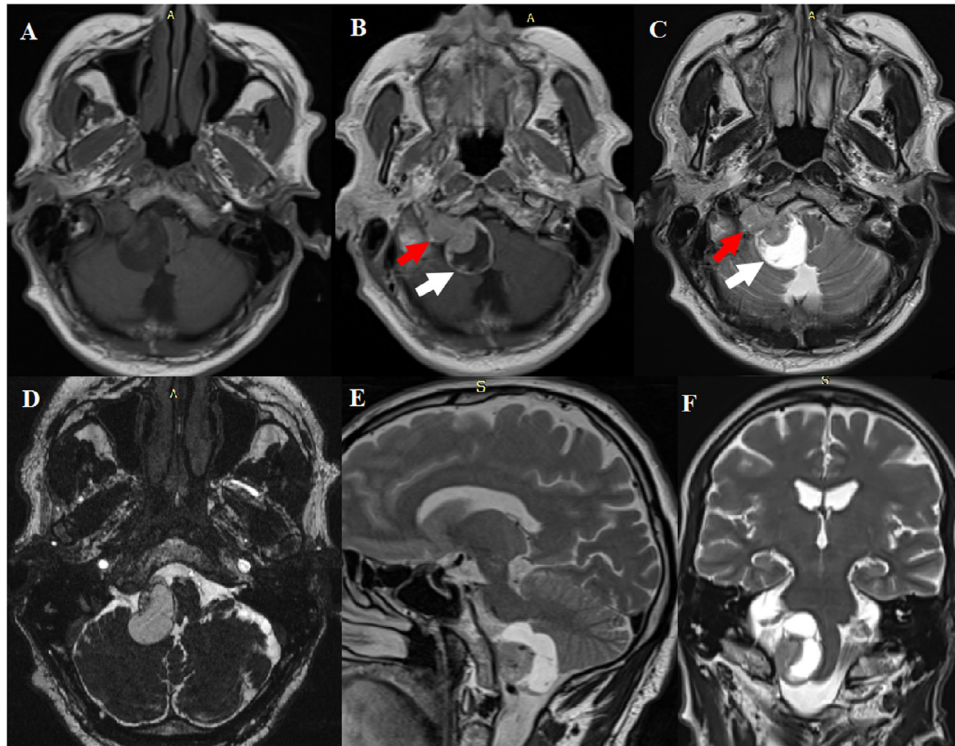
Preoperative Brain Magnetic Resonance Imaging (MRI) axial T1-WI (A), axial T1-WI with gadolinium (B), axial T2-WI (C), axial Constructive Interference in Steady State (CISS) sequence (D), sagittal T2-WI (E) and coronal T2-WI (F) showing a large expanding mass in the right cerebellopontine angle with a cystic component (white arrow). The tumour extends extracranially over the occipital condyle area with marked compression of the cervico-medullary junction (F) and through the enlarged hypoglossal canal with dumbbell-shaped extension to the parapharyngeal space (red arrow).
